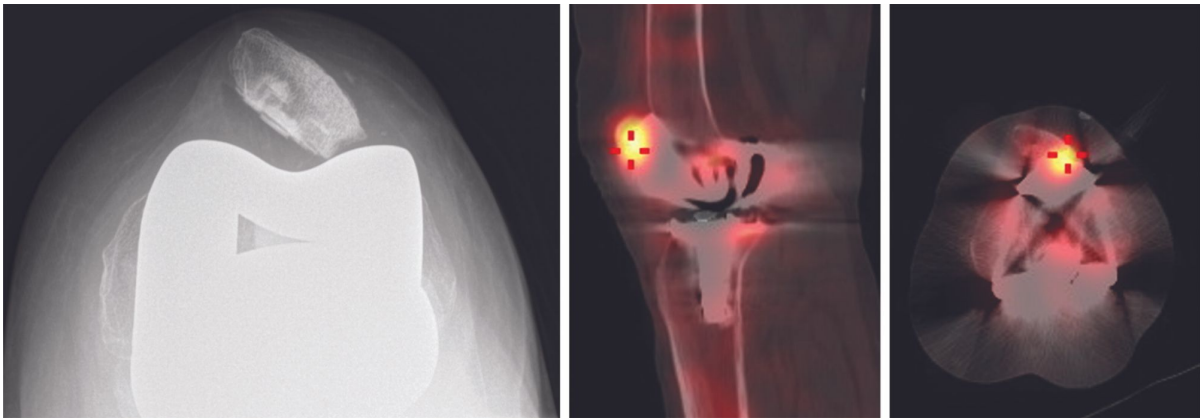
Lateral impingement with patellar tilt, and positive SPECT-CT with hot spot at the patella. Preoperative patellar thickness = 20mm
